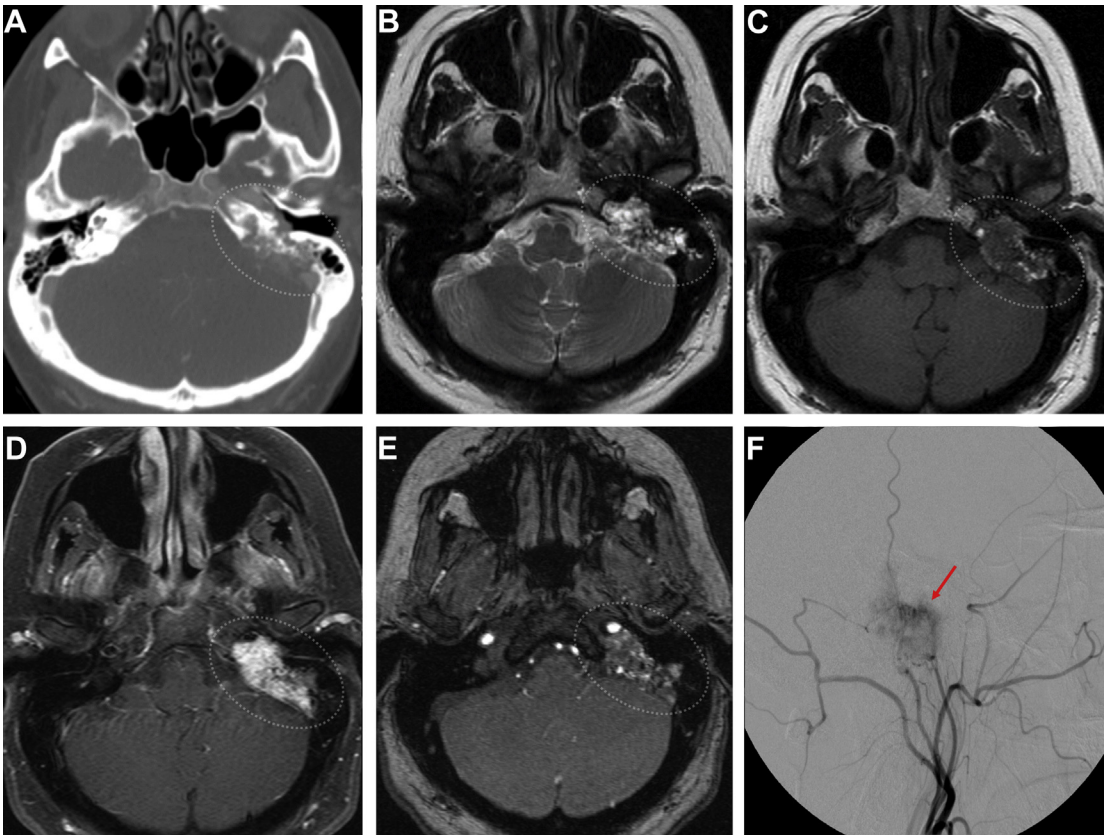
A 59-year-old woman with endolymphatic sac tumor (dotted ellipse) in left temporal bone. (A) Axial CT shows moth-eaten type of osteolysis. (B) Axial T2WI, (C) T1WI, and (D) postcontrast T1WI show left temporal bone mass with areas of T1 shortening and intense postcontrast enhancement. (E) Axial 3D time-of-flight MRA and (F) catheter angiography (left external carotid artery injection) show tumor vascularity (red arrow).
